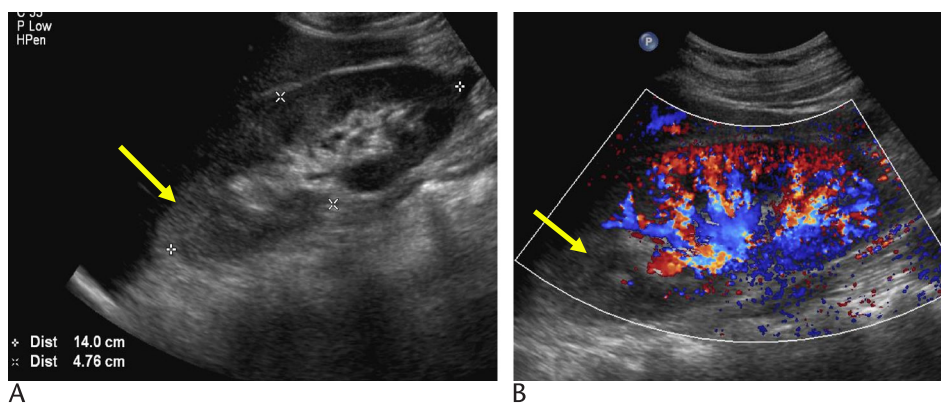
Sagittal gray-scale (A) and color Doppler (B) images of the right kidney demonstrate an enlarged right kidney (measuring 14 cm in length) with focal increased echogenicity, loss of corticomedullary differentiation, and decreased perfusion in the upper pole.
